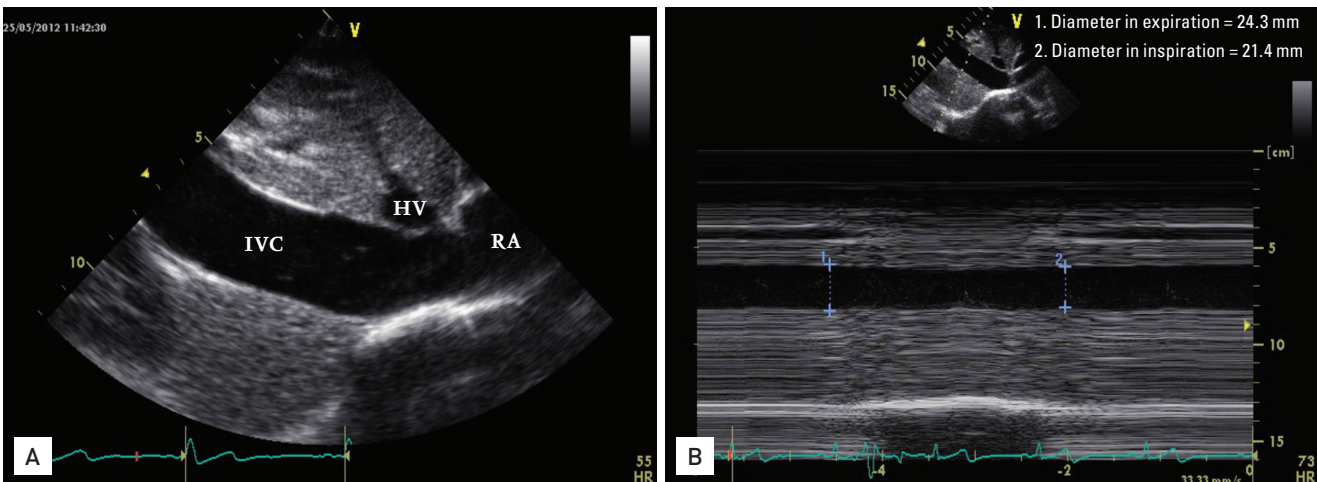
Transthoracic echocardiography showed dilatation of the inferior vena cava (IVC) (24.3 mm in diameter) (A) and diminished inspiratory collapse (B). HV, hepatic vein; RA, right atrial.
